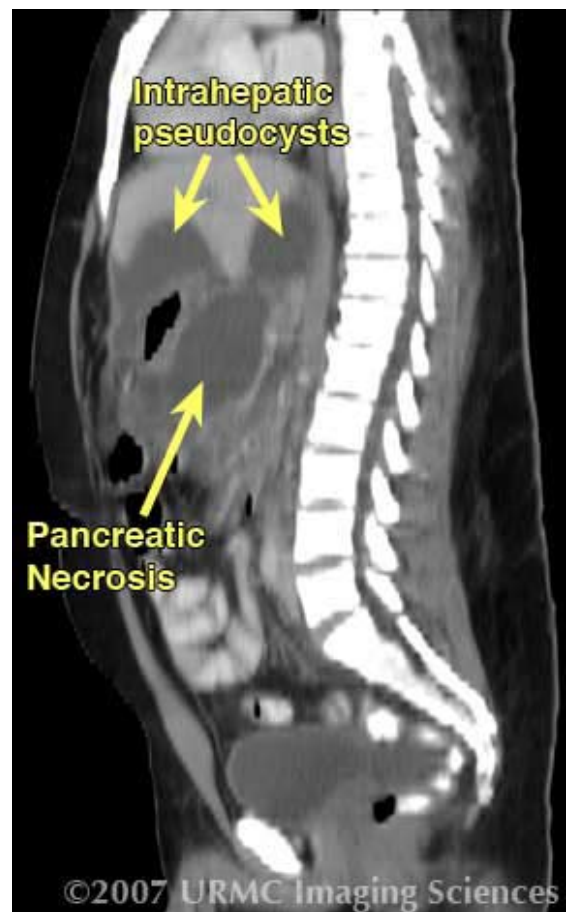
Sagittal CT image demonstrates pancreatic necrosis with adjacent intrahepatic pseudocysts superiorly.
